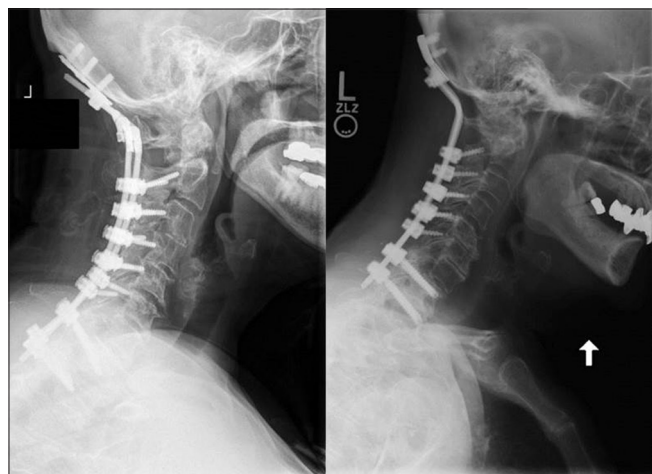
Lateral radiographs demonstrating occipitocervical fusions using hinged rods (left) and contoured rods (right)
